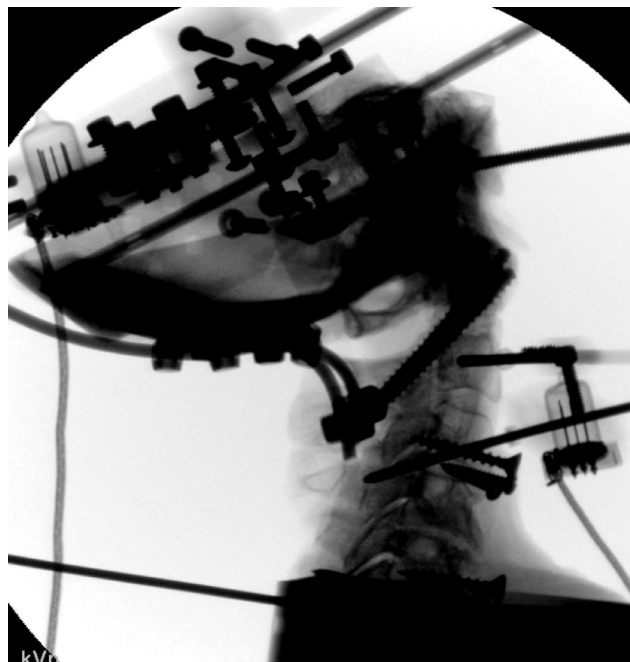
X-ray showing transarticular screw technique using C1–C2 transarticular screws.
